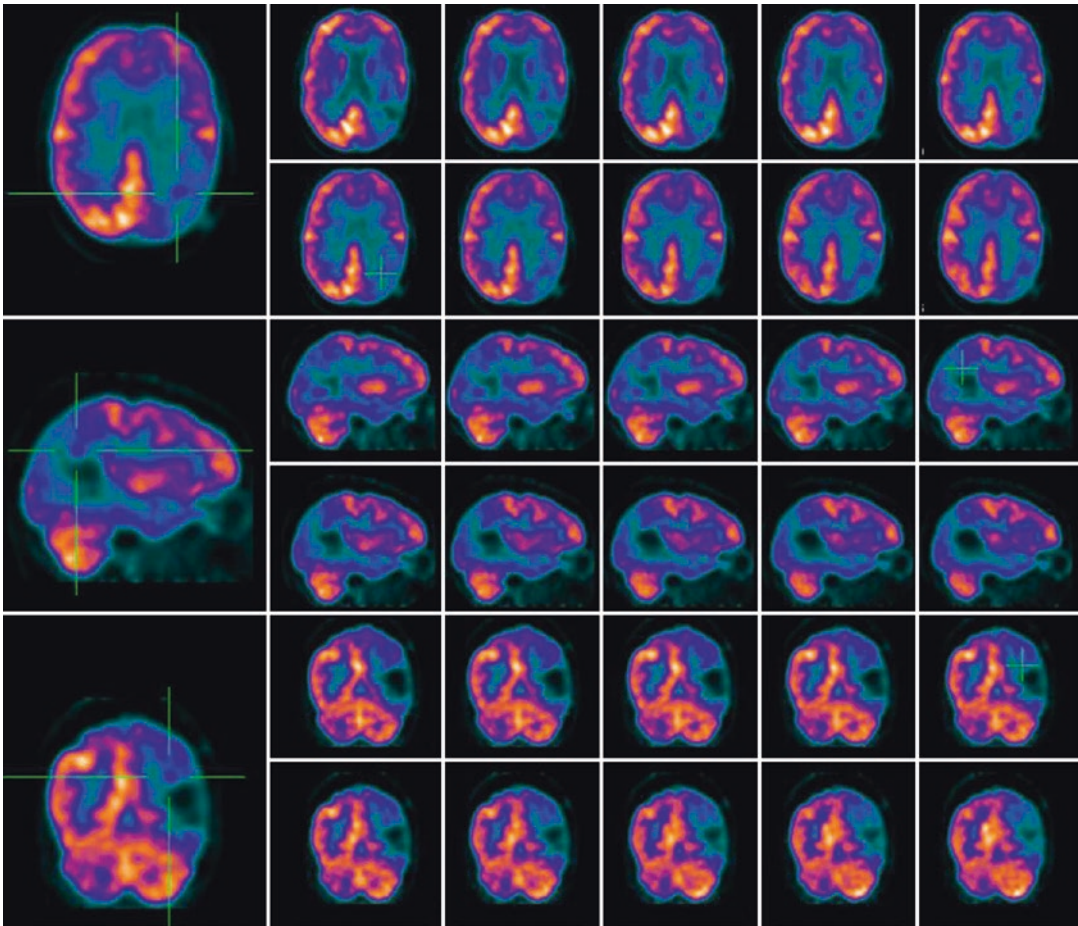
Multiplanar PET evaluation of a patient with a past history of stroke in the left parietal region. The brain ^{18}F -FDG PET was performed 2 years after the ischemic injury and shows deficit of glucose metabolism in the left
